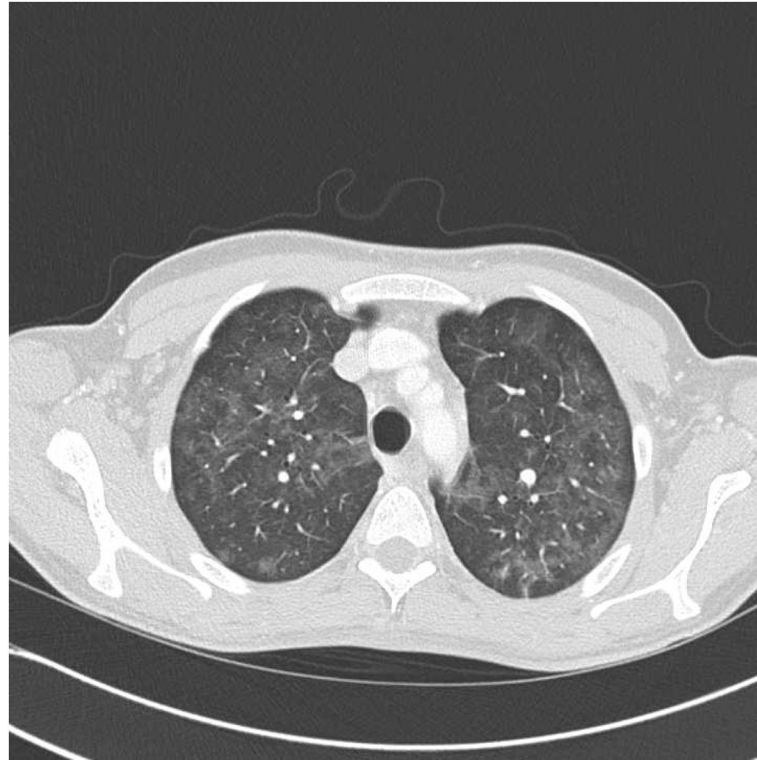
Axial HRCT of the upper chest of an HIV-infected patient with PCP. There are bilateral patchy “ground glass” infiltrates, with sub-pleural sparing.
